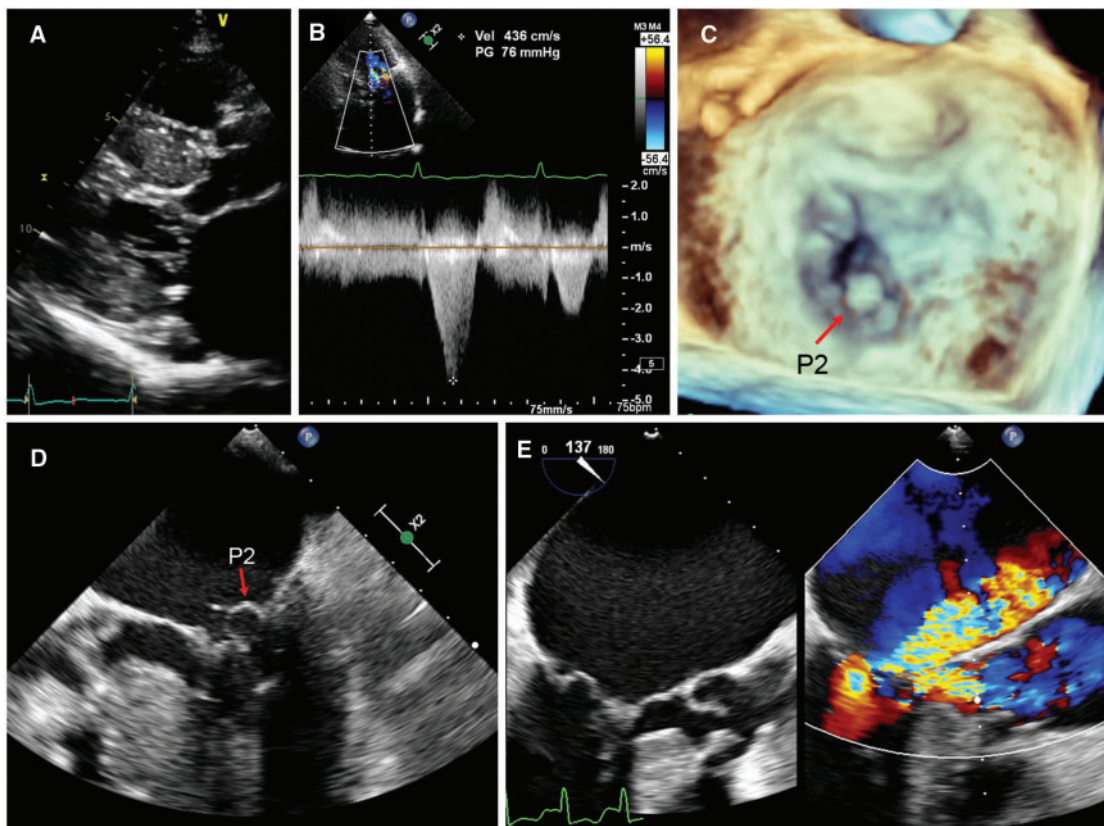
(A) Parasternal long-axis view showing severe left ventricular hypertrophy and systolic anterior motion of the mitral valve. (B) Late-peaking left ventricular outflow tract (LVOT) gradient of 76 mmHg. (C) 3D and (D) 2D transoesophageal echocardiographic mid-oesophageal 4-chamber views showing P2 flail. (E) LVOT view showing severe mitral regurgitation and flow acceleration across the LVOT.
